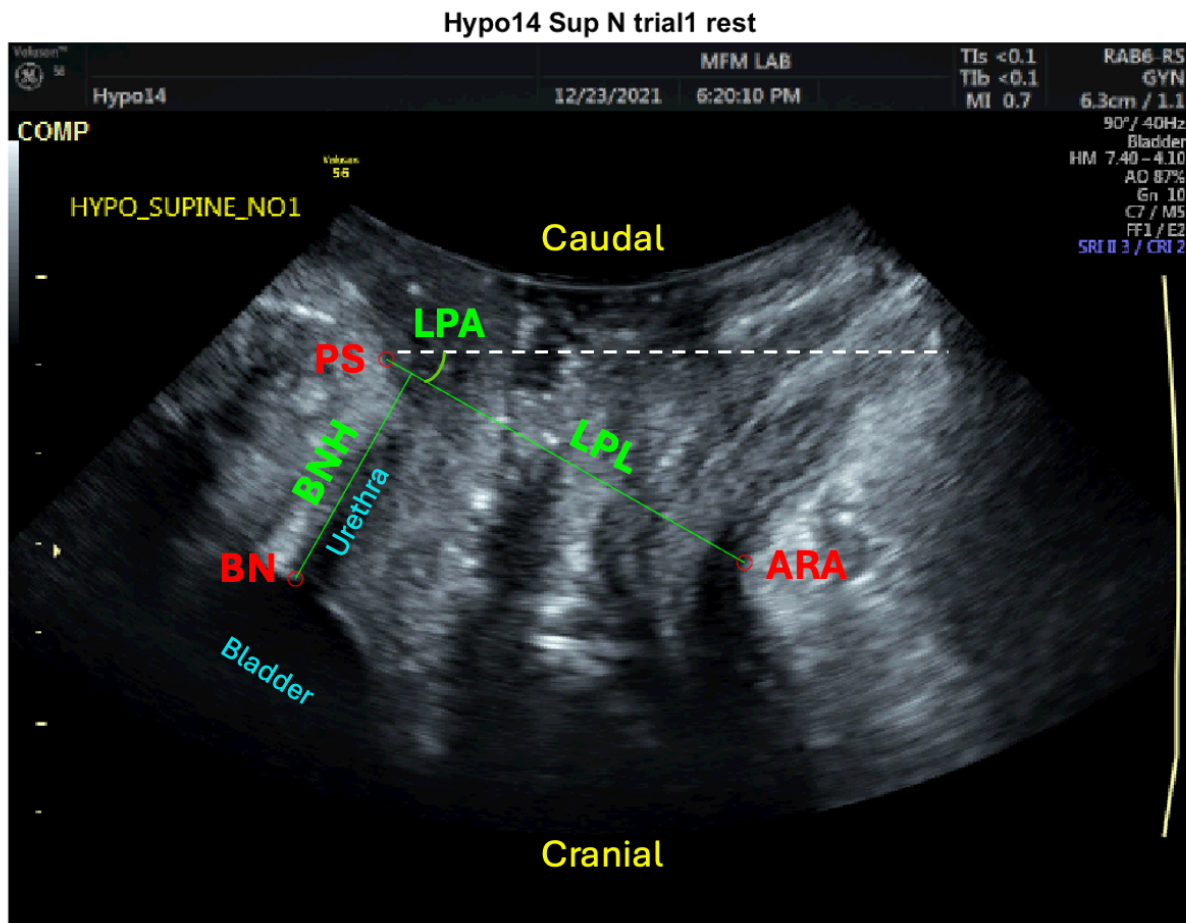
Sample 2D B-mode transperineal ultrasound image of the pelvis. PS: pubis symphysis; BN: bladder neck; ARA: anorectal angle; BNH: bladder neck height – distance between PS and BN that shows cranial-caudal displacement characterizing PFM contraction; LPL: levator plate length – distance between PS and ARA that shows shortening or lengthening of the PFMs; LPA: levator plate angle.
